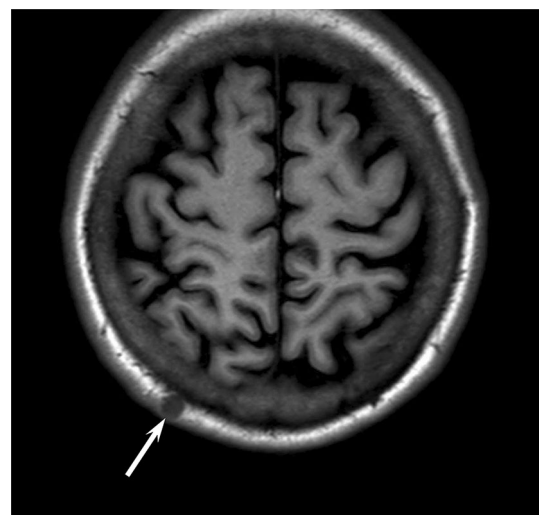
A 62-year-old woman with metastasis from renal cell carcinoma. T1-weighted image shows a hypointense subcutaneous nodule (arrow)
